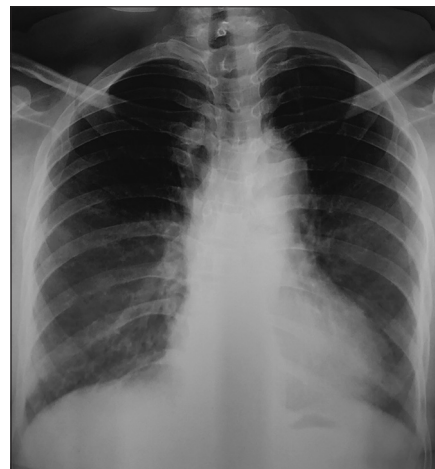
Chest X-ray showing presence of nonhomogenous opacity in the bilateral middle and lower zones
